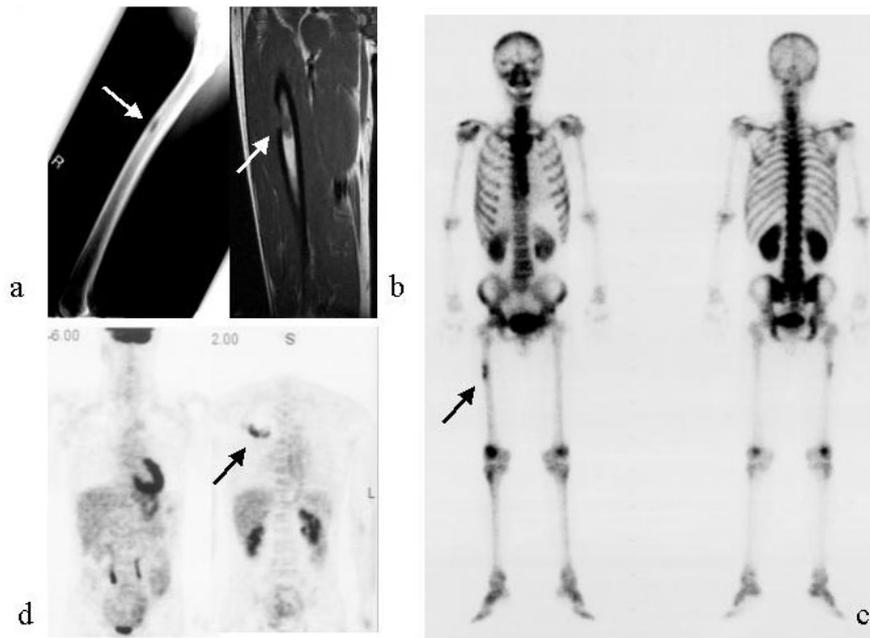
A case of bone metastasis located in the middle of femur (patient #1). Fifty-year-old male patient with lung cancer. At first, the lesion was suspected to be a primary femoral bone tumor. Then the diagnosis was changed to metastatic tumor based on the result of biopsy, which showed a poorly-differentiated carcinoma. Plain X-ray and MRI (T1WI) showed an excentric bone tumor in the right femoral diaphysis (a, b). BS showed high accumulation of ^{99m}Tc -HMDP in the corresponding area (c). FDG-PET was performed to detect the primary tumor, and therefore, FOV of PET scan did not include full-length of the femur. Whole-body scan from inguinal area to face showed high accumulation of FDG in the right upper lobe which was diagnosed as lung cancer later (d).
